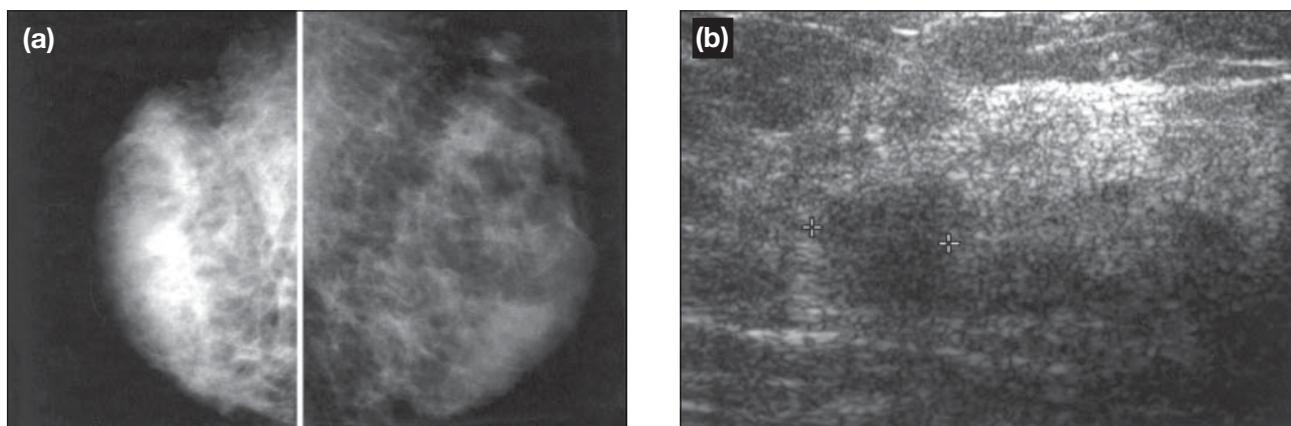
Ovarian metastasis. (a) A 39-year-old woman with a known history of malignant ovarian tumour with brain metastases presented with hardening of the whole right breast. Bilateral medio-lateral oblique views show shrinkage of the right breast with increased density over the superior and central regions. (b) Ultrasound study shows a round hypoechoic mass with irregular outline in the right breast. Biopsy confirmed ovarian metastases.
